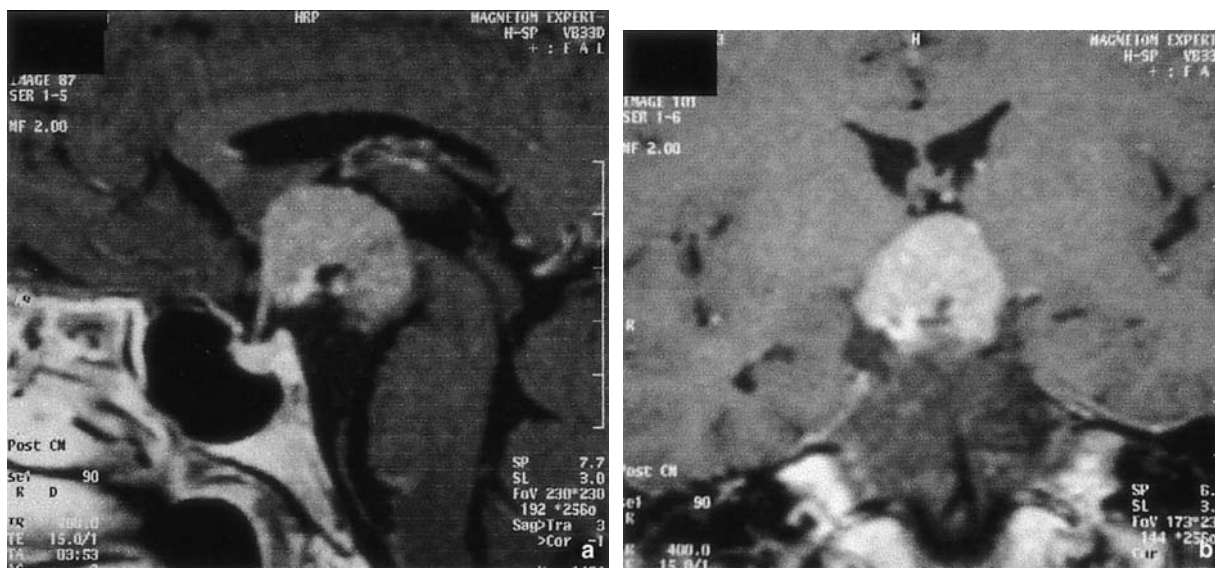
First postoperative sagittal (a) and coronal (b) gadolinium enhanced T1-weighted MRI demonstrating complete removal of the lower portion of the tumour in the prepontine region
